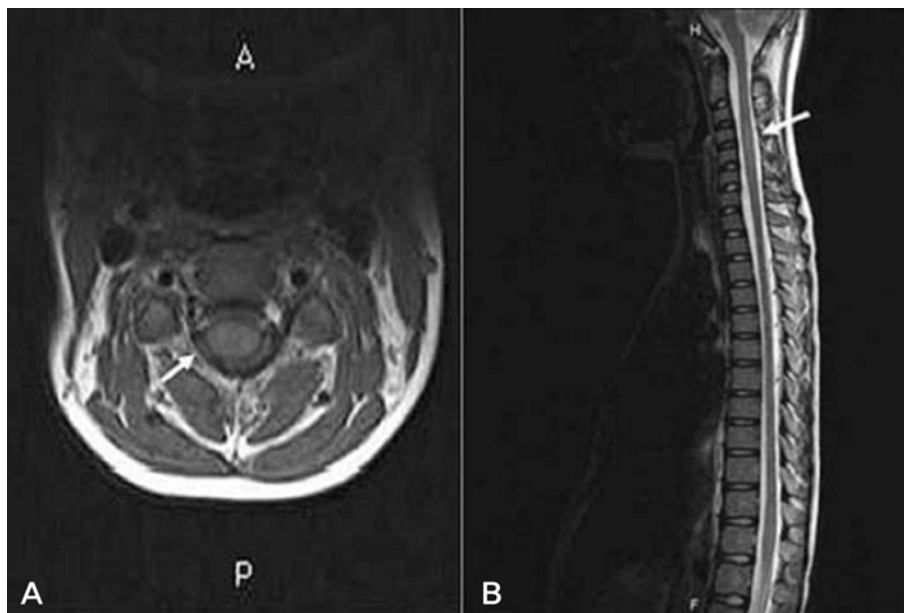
On a follow-up MRI performed on the 11th day, T1-weighted axial image (A) shows a marked improvement (arrow) of the edematous swelling of the cord. T2-weighted sagittal image (B) shows normal findings (arrow) of the spinal cord without an edematous lesion.
